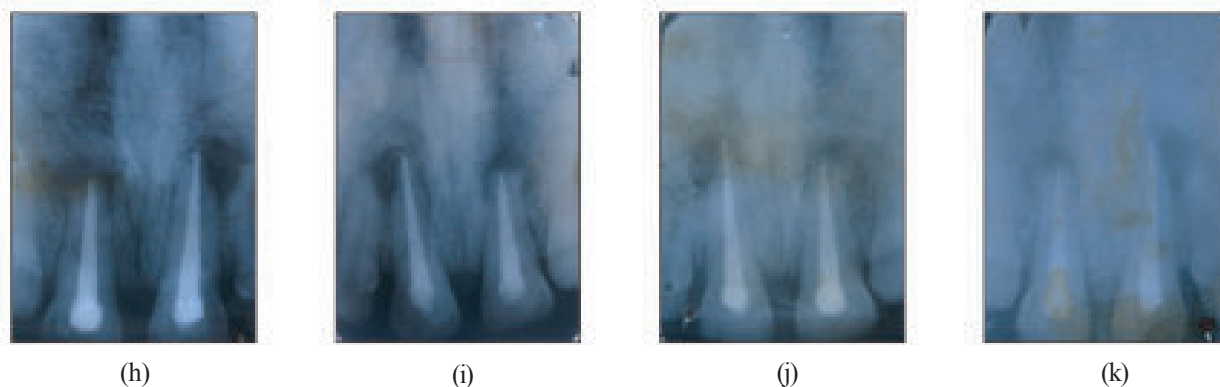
Follow up radiographic view of the same teeth just after root canal obturation (h), at 6 months interval (i), at 12 months interval (j) and at 24 months interval (k).
